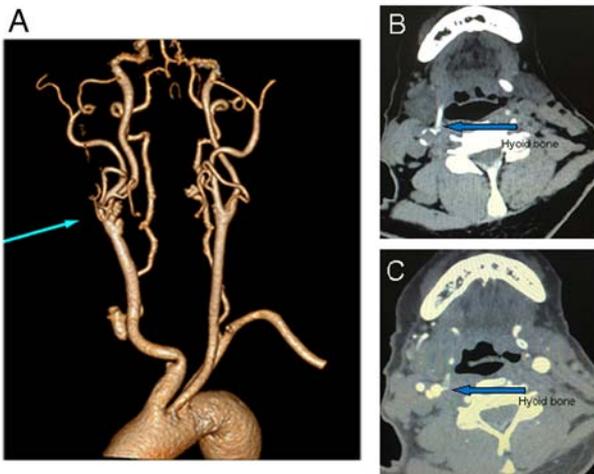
Contrast-enhanced computed tomography revealed two cysts with some calcification. (A) CTA with 3D reconstruction revealed two cysts with some calcification located at the bifurcation of the right ICA and stenosis of the origin of the right ICA. Computed tomography (B) without or (C) with contrast material revealed the greater horn of the right side of the hyoid bone adjacent to the right ICA. CTA, computed tomography angiography; ICA, internal carotid artery.
